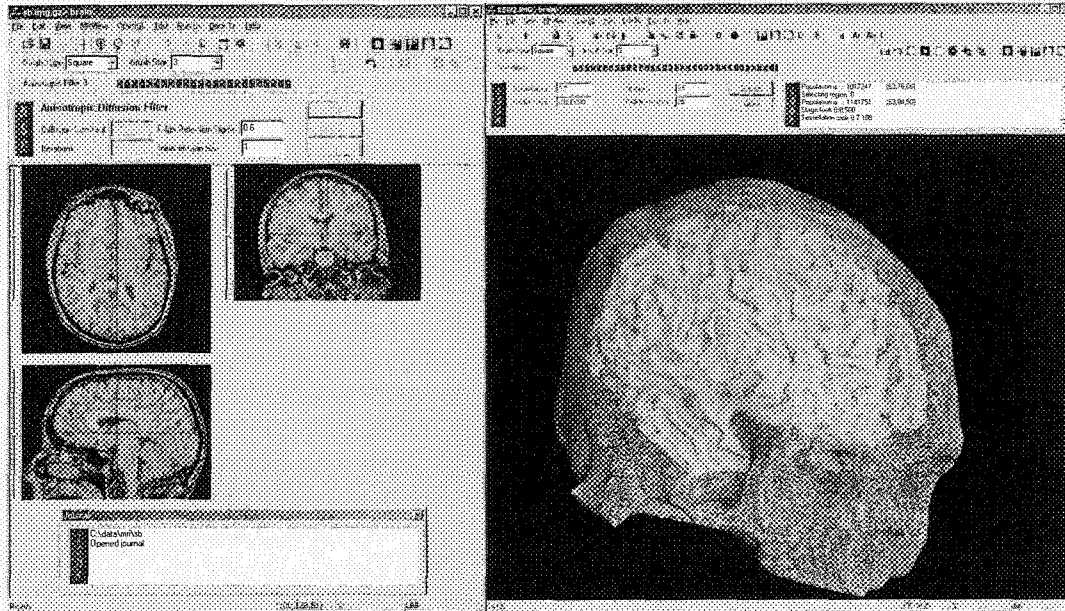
The BrainSuite surface identification tools in (left) orthogonal MRI display mode and (right) surface display mode.
